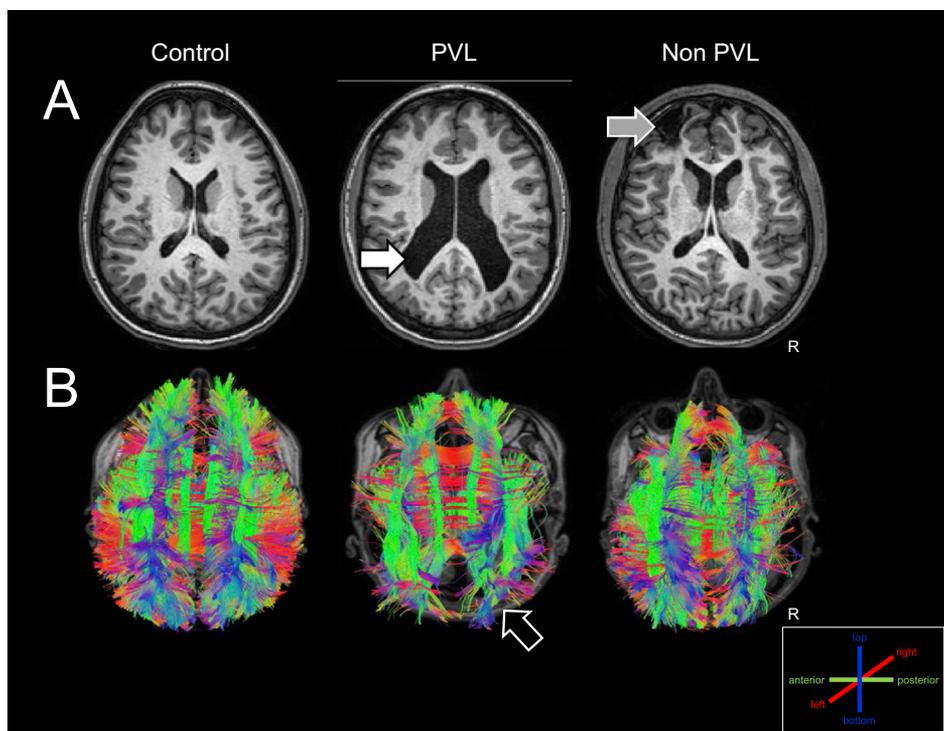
(A) Axial T1-weighted MRI images in a normally sighted control (19-year-old girl; no history of visual dysfunction; left panel) and an individual with CVI born prematurely (16-year-old girl; 20/60 is standard Snellen clinical notation visual acuity; middle panel) and another individual with CVI born at term (19-year-old boy; 20/100 is standard Snellen clinical notation visual acuity; right panel). Note the presence of enlarged lateral ventricles characteristic of periventricular leukomalacia (PVL) (white arrow, middle panel) compared to the control individual. In contrast, the lateral ventricles appear normal in the individual with CVI born at term (right panel). However, areas of focal cortical and white matter damage are apparent (gray arrow). With standard MRI imaging, no further information is provided beyond gross anatomic changes. (B) Corresponding axial view of whole-brain white matter tractography reconstruction in the same individuals revealed with diffusion MRI (HARDI). Note the robust arborization present throughout the brain in the control individual. In contrast, evidence of decreased white matter connections (including the occipital pole; black arrow) is evident in the individual born prematurely with CVI due to PVL (middle panel). In the individual with CVI born at term (right panel), white matter connectivity appears reduced, but not as dramatic as in the individual with PVL. Color scheme corresponds to fiber orientation plane (green: anterior to posterior, red: left to right, blue: head to feet). White matter fiber tracking and reconstruction was performed using DSI Studio software (<http://dsi-studio.labsolver.org/>). Both T1-weighted and HARDI images were acquired in the same scanning session. HARDI images were acquired with an 18-min scan time. (Modified with permission from Hirsch et al.⁷⁷) (Color version of figure is available online.)
